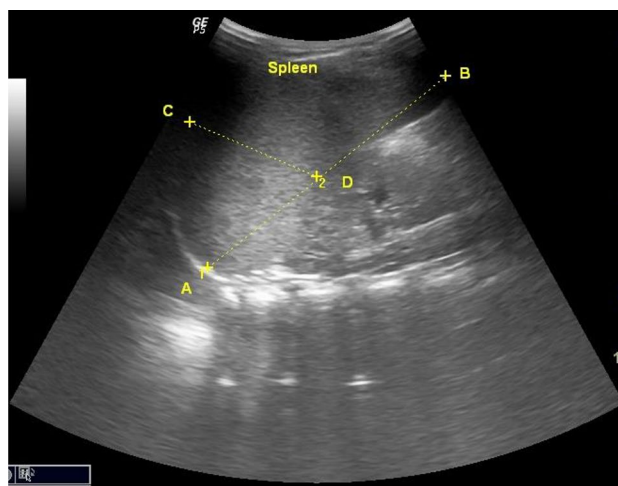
A B-mode coronal ultrasound image through the spleen showing the spleen and the left kidney. (AB = Splenic length)
